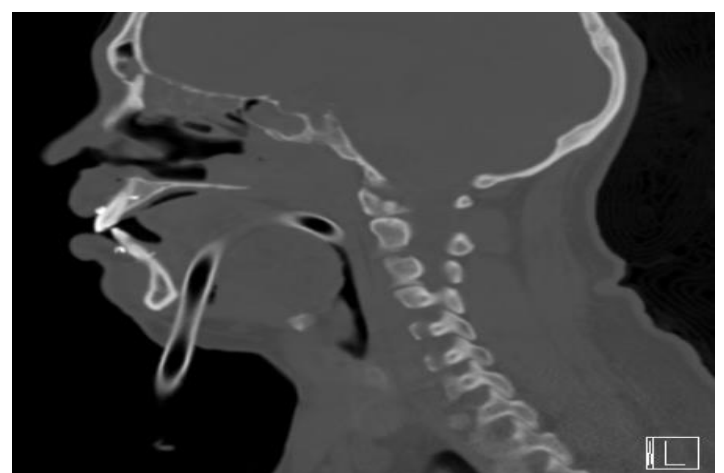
Post-reduction sagittal computed tomography scan demonstrating appropriate placement of the submental tube.
